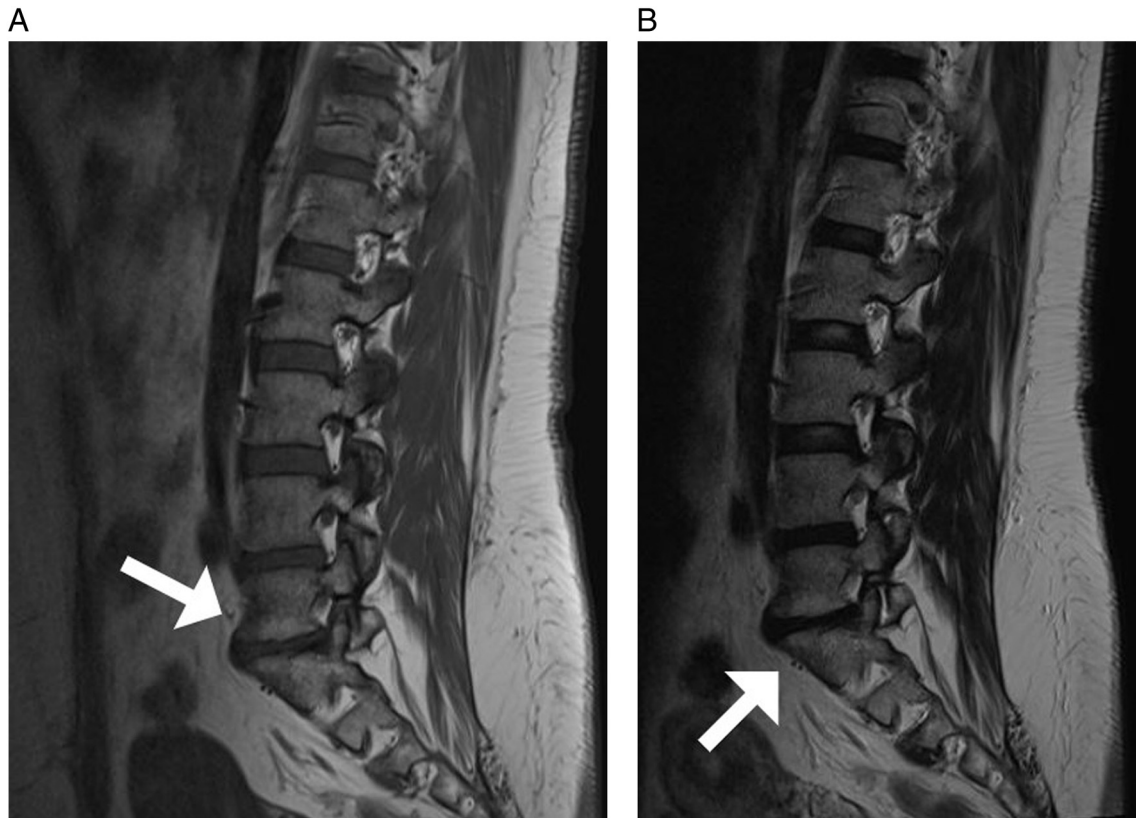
Magnetic resonance imaging of the lumbar spine, sagittal slices, T1-weighted (A) and T2-weighted (B), showing a Modic change type II at the lower vertebral endplate of L5 and at the upper vertebral endplate of S1.
